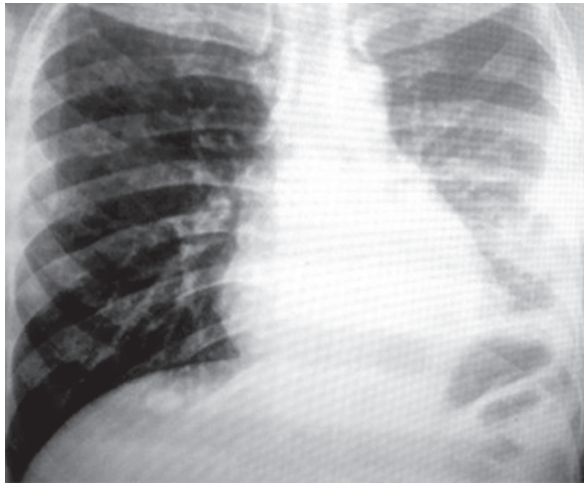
Chest X-ray at the time of discharge of the patient
